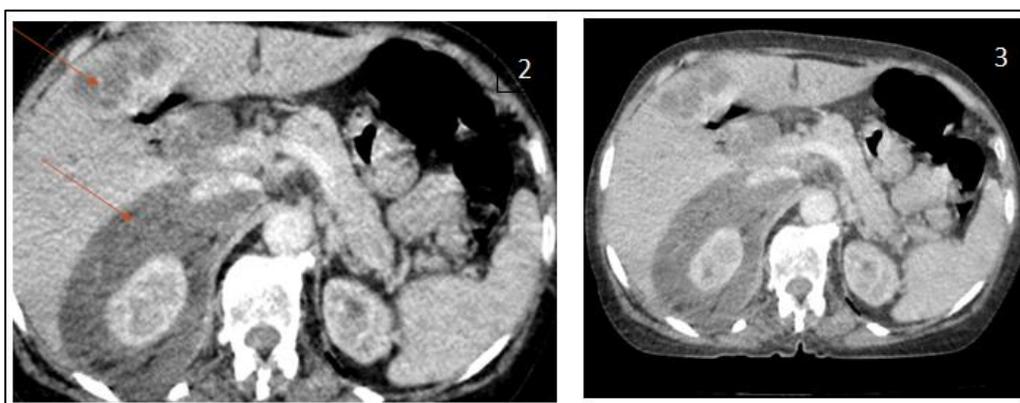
Abdominal CT scan with contrast injection: Dilatation of the intrahepatic bile ducts with individualization of two hepatic cystic formations (metastases on anatomical examination) enhanced in the periphery after contrast injection.
